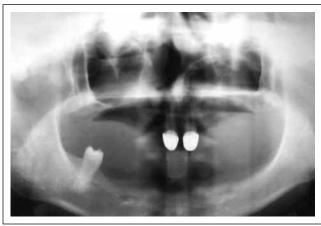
Panoramic radiograph of the patient 3.
